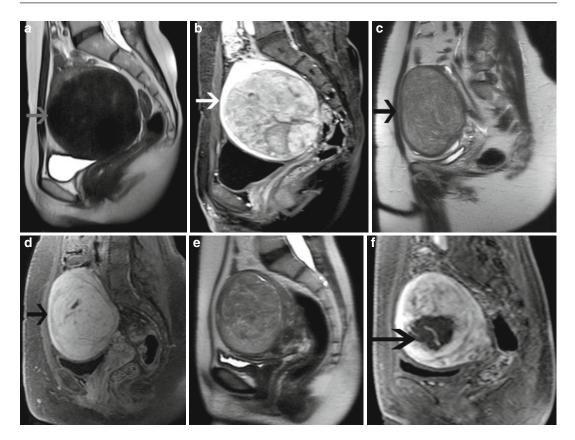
MR imaging and enhancement characteristics of individual leiomyomas can be classified as classical, hypercellular, or degenerating. Classical fibroids appear hypointense on T2-weighted sequences (a) and enhance on gadolinium-enhanced T1-weighted sequences (b).
